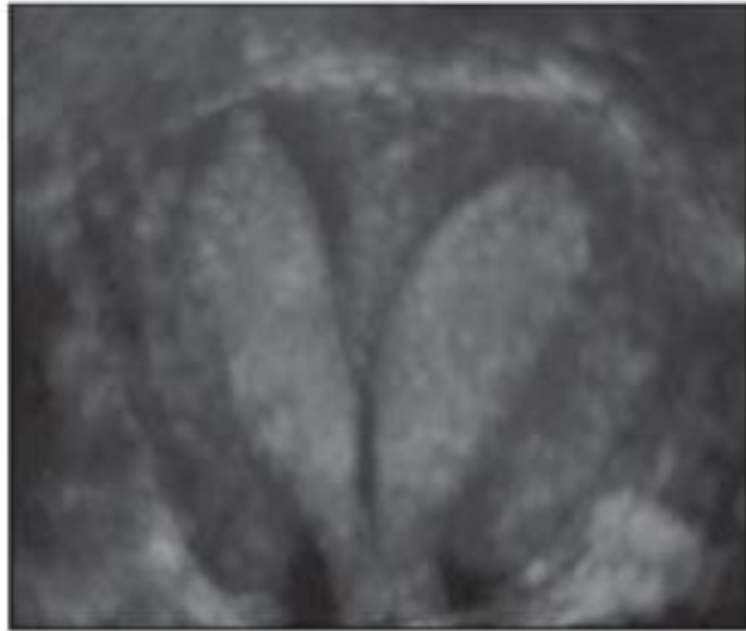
Double cavity uterus. Final diagnosis: septate uterus. Evaluation by multiplanar, transvaginal 3D ultrasound. Observe the symmetrical endometrial cavities.
